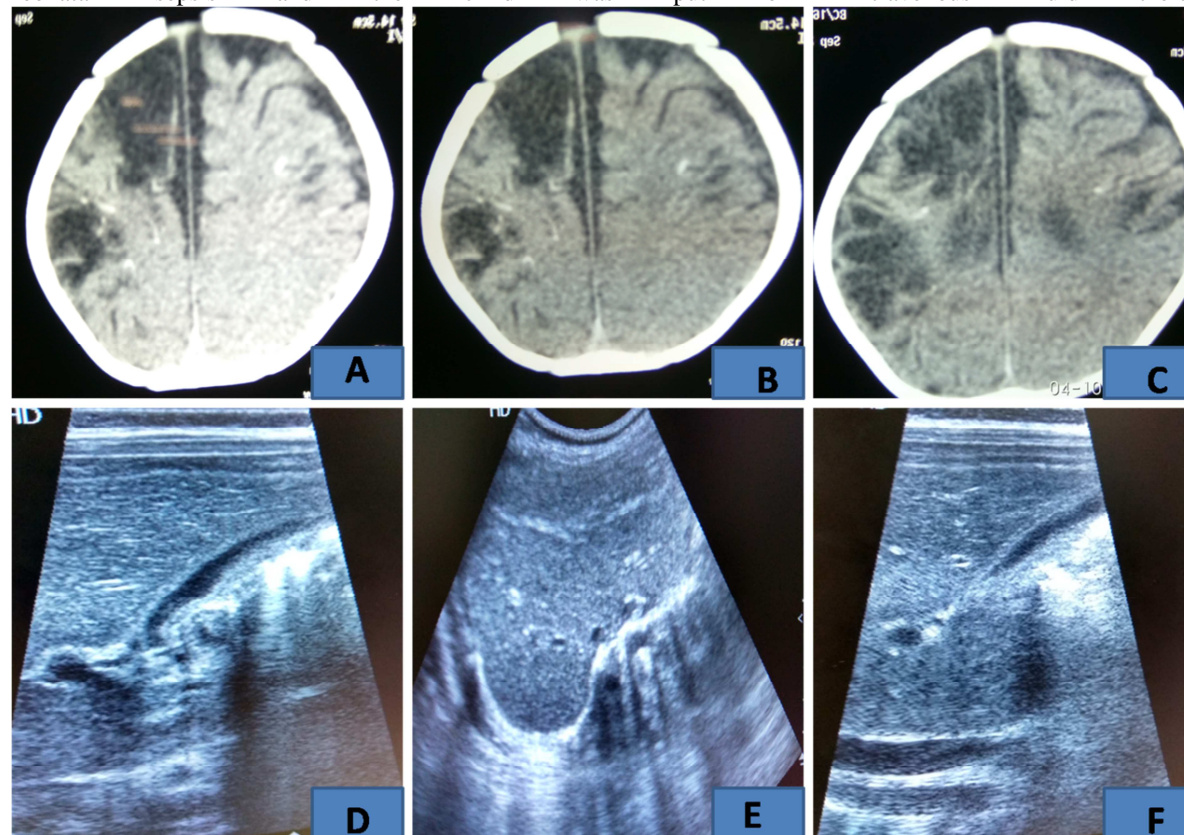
A, B, C- CT scan of brain
